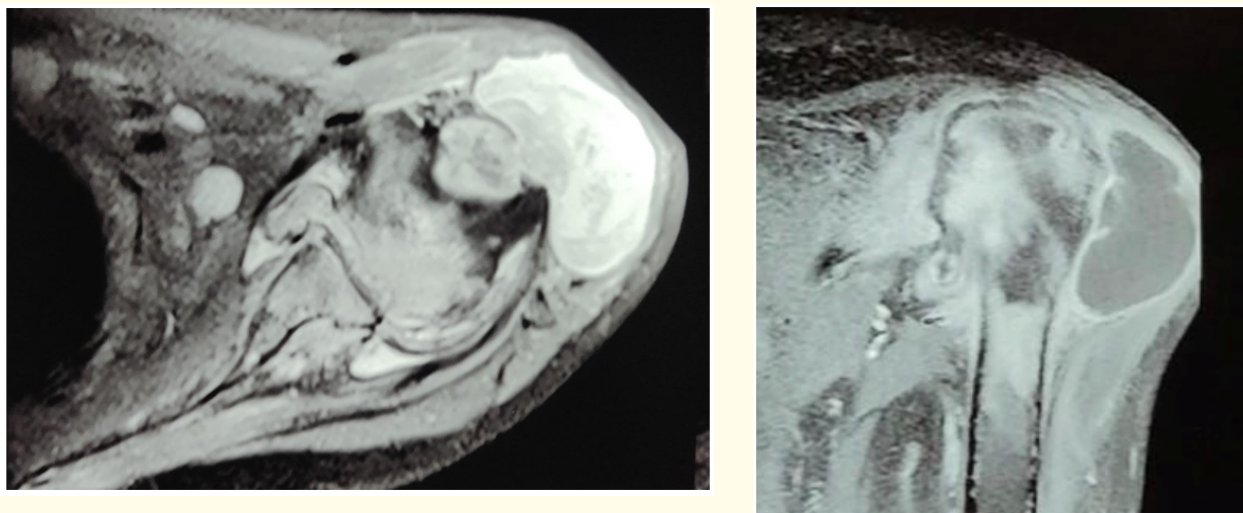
MRI showing cold abscess.
